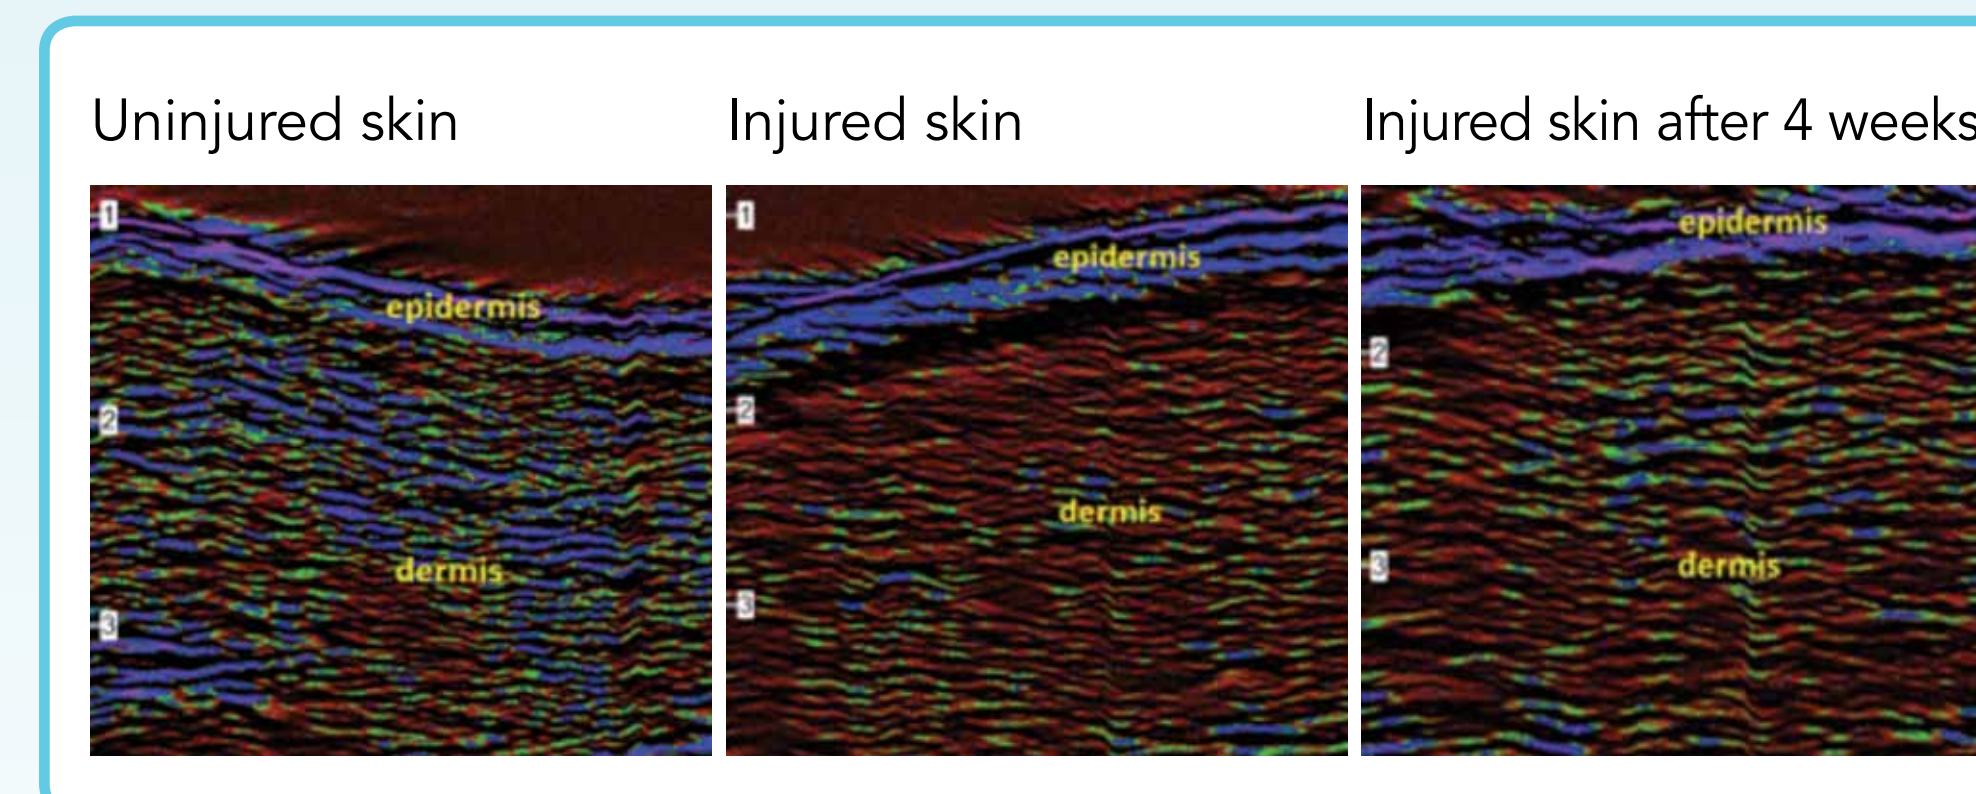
Ultrasound scan of the Mepilex Border treated heels
